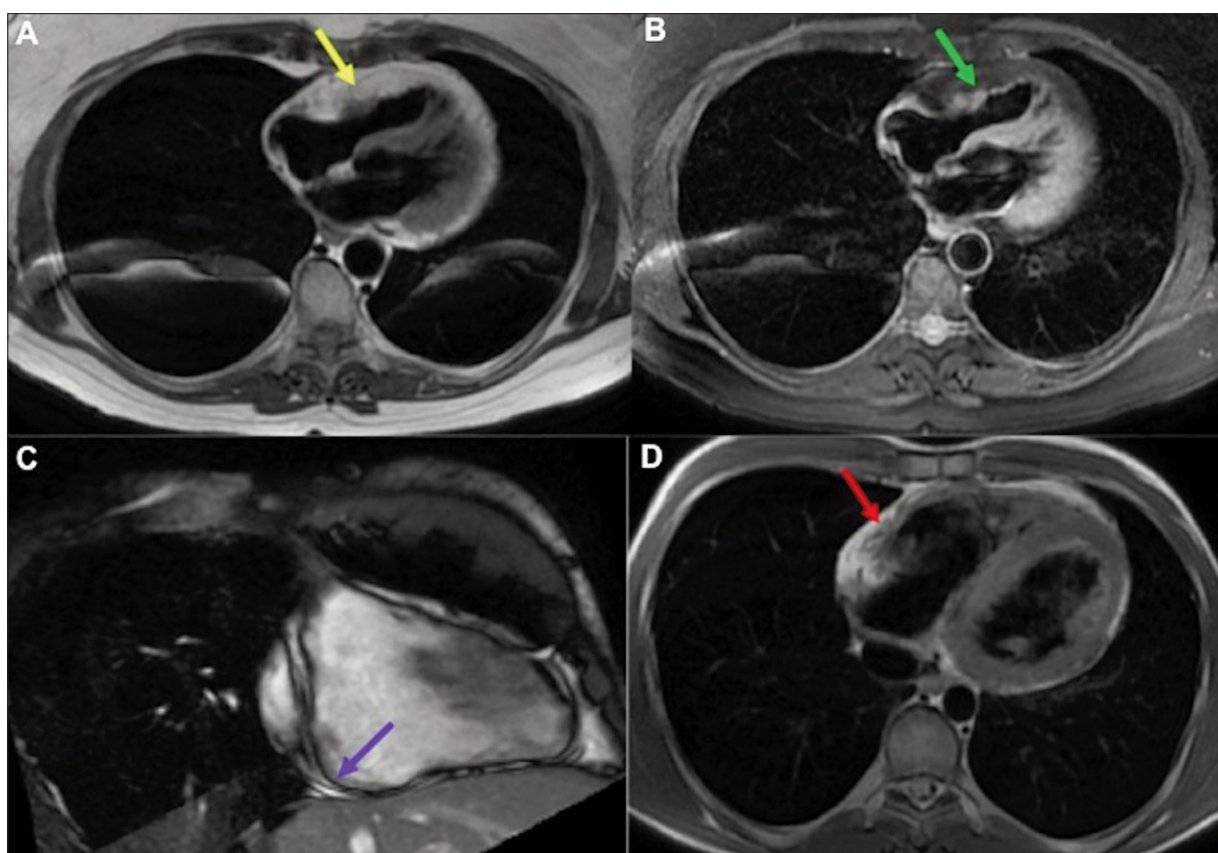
A-B*, Axial double inversion recovery magnetic resonance imaging (MRI) delineated a thickened right ventricular (RV) free wall measuring 12 mm with diffuse hyperintense signal (*yellow arrow*) that suppresses on fat-suppressed image (*green arrow*), indicating diffuse lipomatous infiltration of myocardium in the RV free wall. No RV aneurysm, akinesia, or dyskinesia was appreciated. Ratio of RV end-diastolic volume to body surface area was 50 ml/m², and RV ejection fraction was 46%. *C-D*, Displayed for comparison are images from a patient with arrhythmogenic right ventricular cardiomyopathy at our center. Fast imaging employing steady-state acquisition MRI showed a right ventricle with focal aneurysm (*purple arrow*). Cine image (*not shown*) demonstrated dyskinesia of this aneurysm. RV function was decreased with ejection fraction of 25%. Axial double inversion recovery MRI showed no fatty infiltration (*red arrow*).
